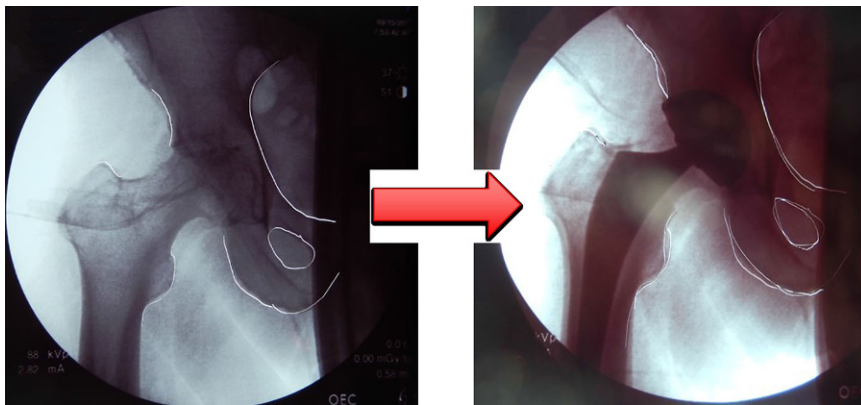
▲ Overlay technique for leg length and offset. The pelvis and femur are outlined and compared to the final x-ray. In this case the patient did not notice any differences in the length preoperatively and did not desire any change in length
